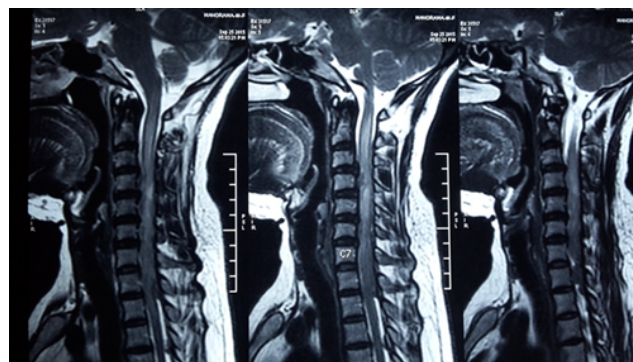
(MRI Picture of a LETM)
